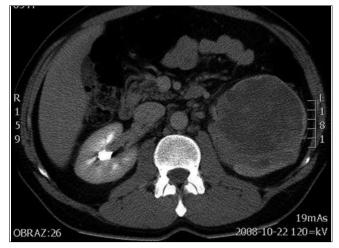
Case II. CT scan revealing heterogenic, irregular hypoattenuated bulk mass in central part of left kidney, measuring 100 x 100 x 120 mm with infiltration of perirenal fat. Contrast enhancement 35 HU to 55–60 HU.
